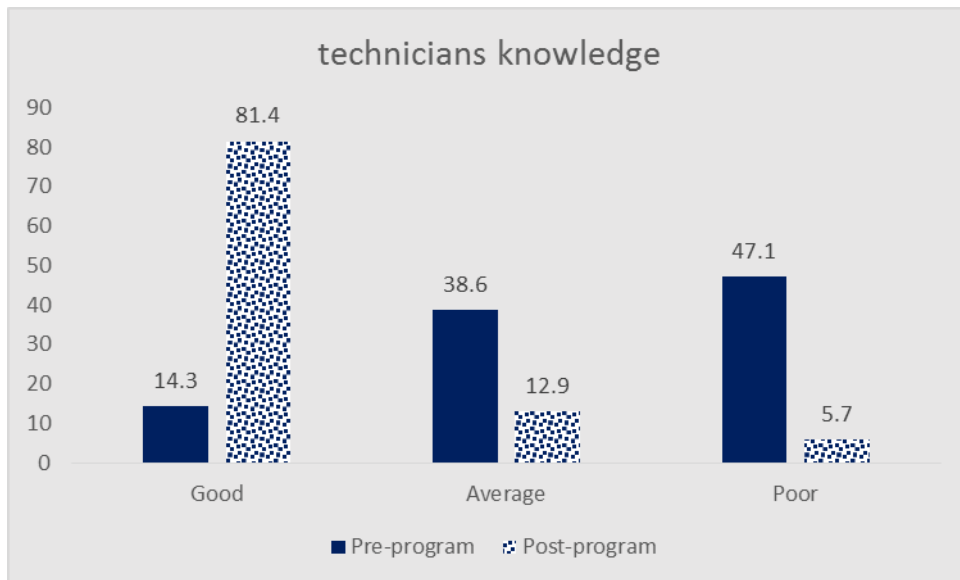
Distribution of the studied radiographers regarding their total knowledge level pre and post program implementation (n=70).
